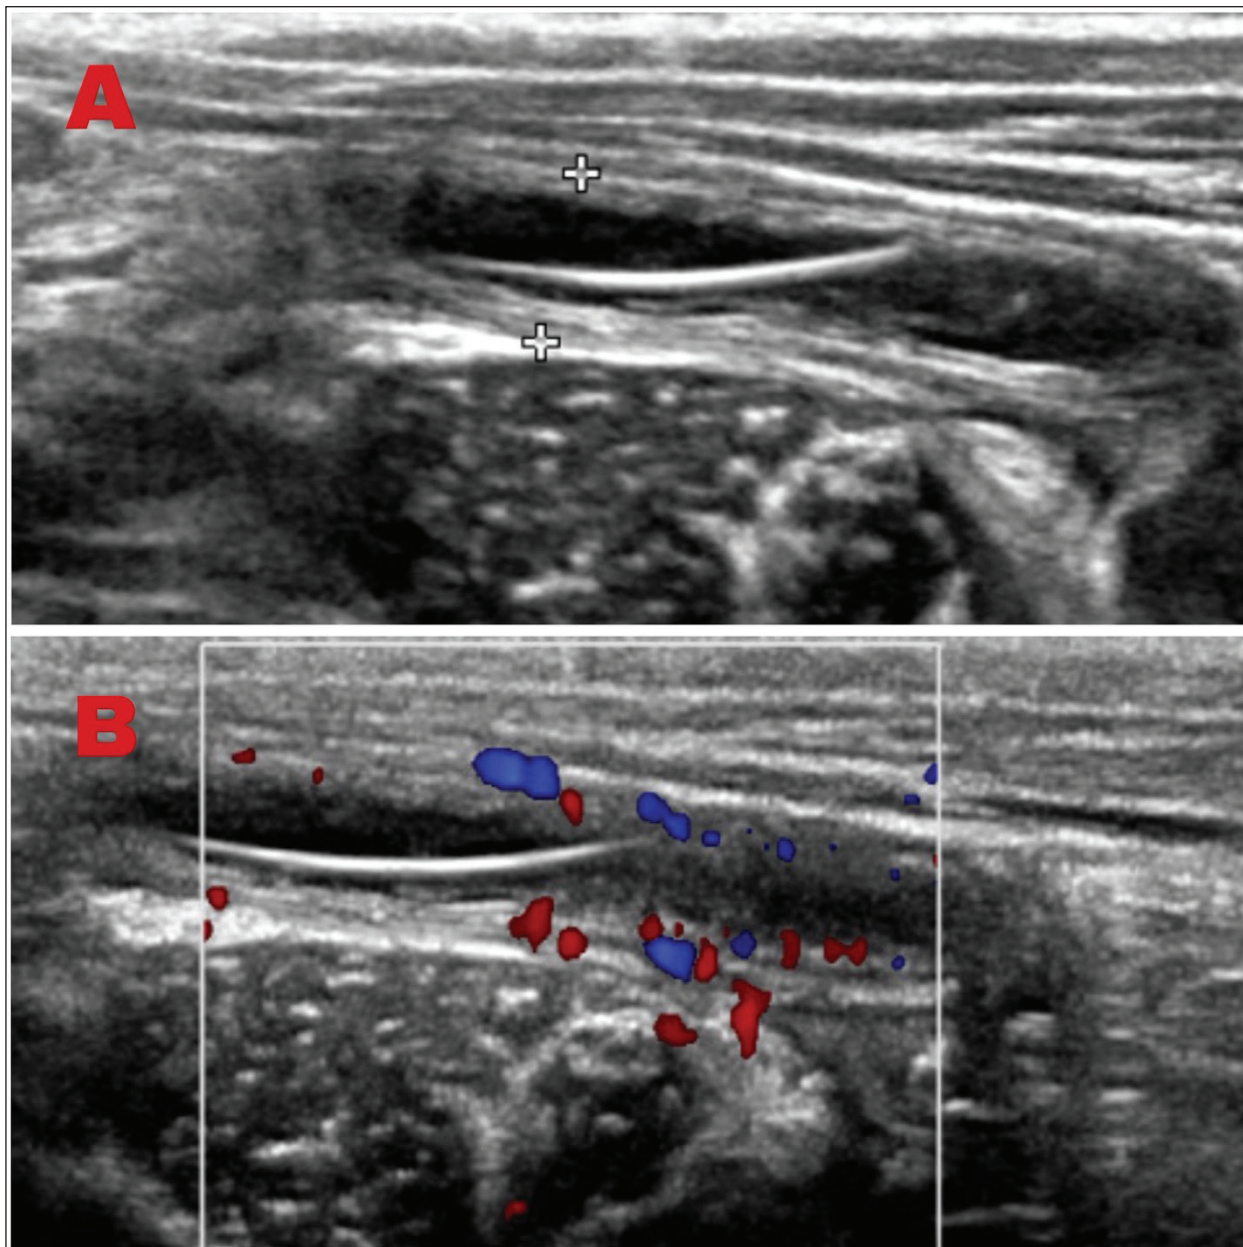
Fishbone identification in the abdominal cavity (A, B). Vascularity increased after applying color mode by ultrasonography, which indicates an inflamed appendix and shows an echogenic foreign body that appears bright on ultrasonography because of its ability to reflect sound waves, typically indicating a solid or dense material.
